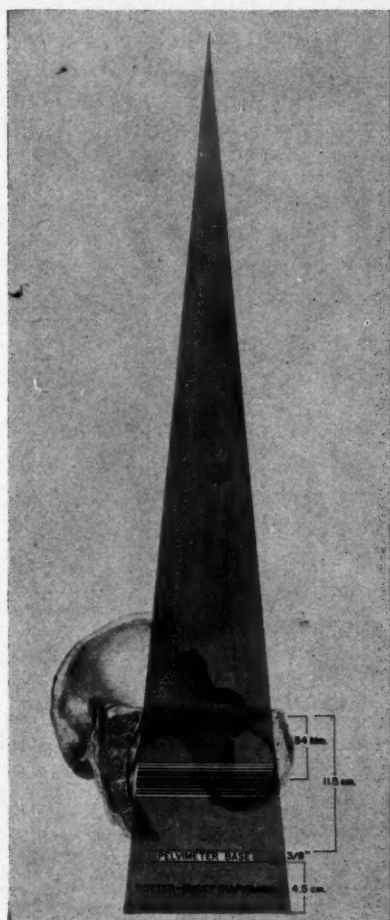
Outline of divergence of the roentgen rays in average female pelvis using Torpin-Thoms Roentgenpelvimeter. Tube-cassette distance, 30 inches. Potter-Bucky diaphragm, 4.5 cm.; pelvimeter base,  $\frac{3}{8}$  inches; pelvic inlet height 11.5 cm.; ischial spines, 54 mm. below inlet with variation in a band of 15 mm. above or below.
